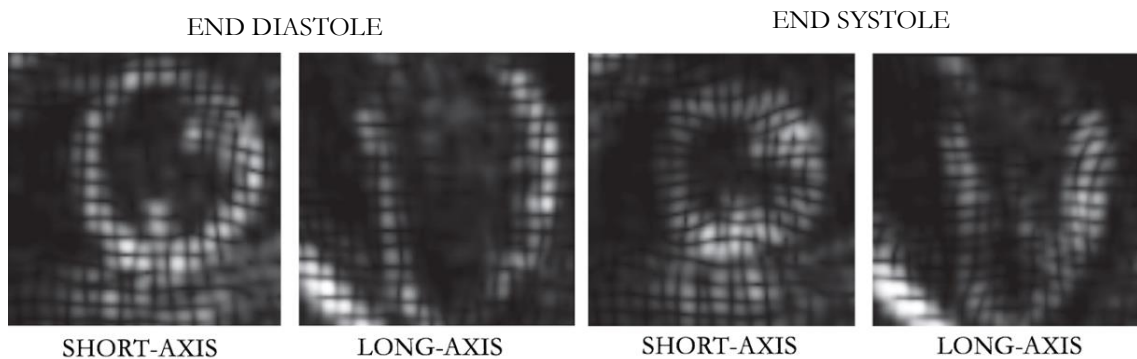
Tag-MRI images corresponding to end diastole and end systole cardiac phases for both short-axis and long-axis [23].
